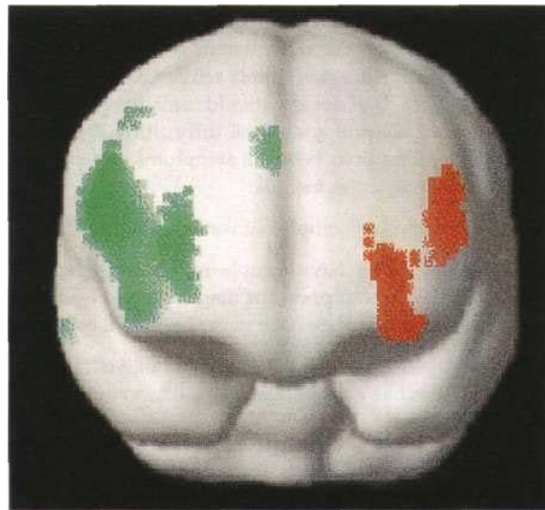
Statistical parametric maps superimposed on an MRI scan of the anterior surface of the brain, orientated as though looking at a person head on. Red region shows hypofunction of patients with conversion motor symptoms. Green region shows hypofunction of healthy controls feigning the same motor abnormality. Reproduced from Spence SA, Crimlisk HL, Cope H, Ron MA, Grasby PM (2000) Discrete neurophysiological correlates in prefrontal cortex during hysterical and feigned disorders of movement. *Lancet* 355:1243-1244, © The Lancet Ltd. 2000, with permission.
